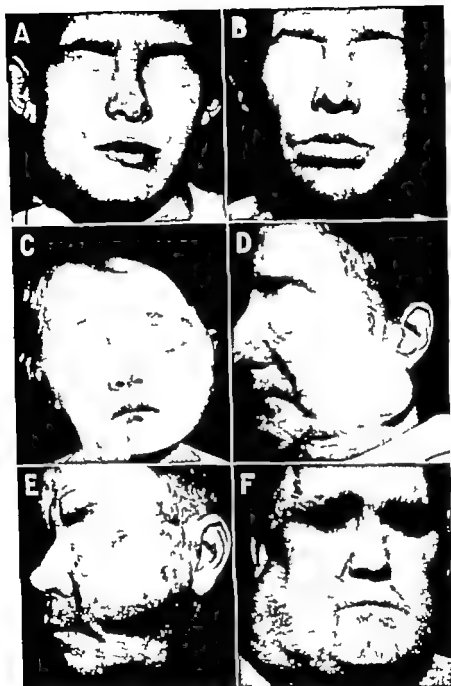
Differential diagnosis of swellings of the face A, acute facial abscess of dental origin. B actinomycosis, a chronic infection. C lipoma, a benign fatty tumor which, because more radiolucent than normal tissue can be diagnosed by roentgenogram D mixed tumor of parotid gland, it grows slowly may be present for many years and may become malignant. E squamous cell carcinoma of the cheek, highly malignant. F adenocarcinoma of parotid gland, highly malignant.
